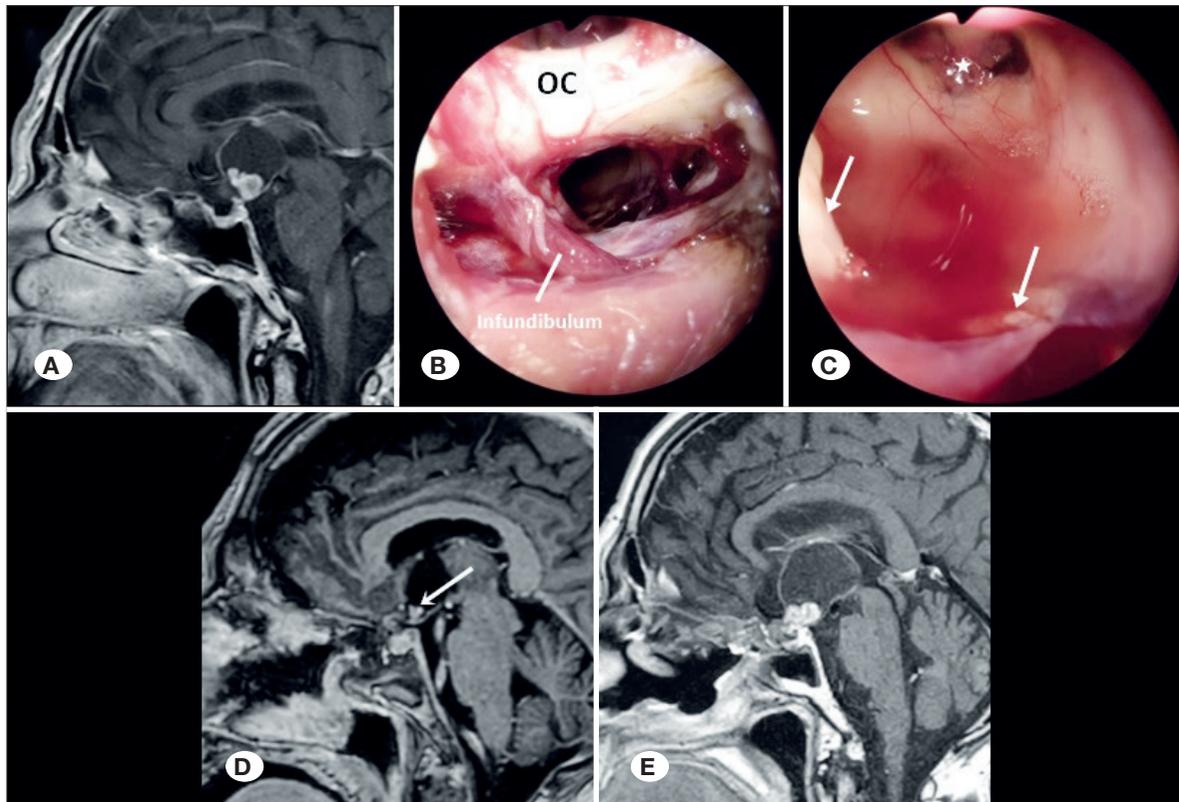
A 66-year-old male with Craniopharyngioma A) Preoperative T1-weighted contrast-enhanced sagittal MRI revealing a mass measuring 32 × 25 × 27 mm in the suprasellar region with a cystic component and an approximately 12 mm diffuse contrast-enhanced solid component. B, C) In intraoperative images obtained through endonasal transnasal transsphenoidal approach, a deviation of the pituitary stalk to the right was observed and preserved. The tumor capsule was visualized posterior-inferior to the optic chiasm. Following near-total resection, the walls of the third ventricle were intact, and both foramina of Monro were open. Residual capsule fragments adhered to surrounding structures are observed (arrows). OC, Optic Chiasm; Stlk, Pituitary Stalk; *, choroid plexus. D) Postoperative twenty-four hours, T1-weighted contrast-enhanced sagittal MRI showing residual tumor fragments (arrow) after near-total resection. E) Postoperative fourth month, T1-weighted contrast-enhanced sagittal MRI displaying a recurrent mass measuring 30 × 20 × 25 mm in the suprasellar region.
